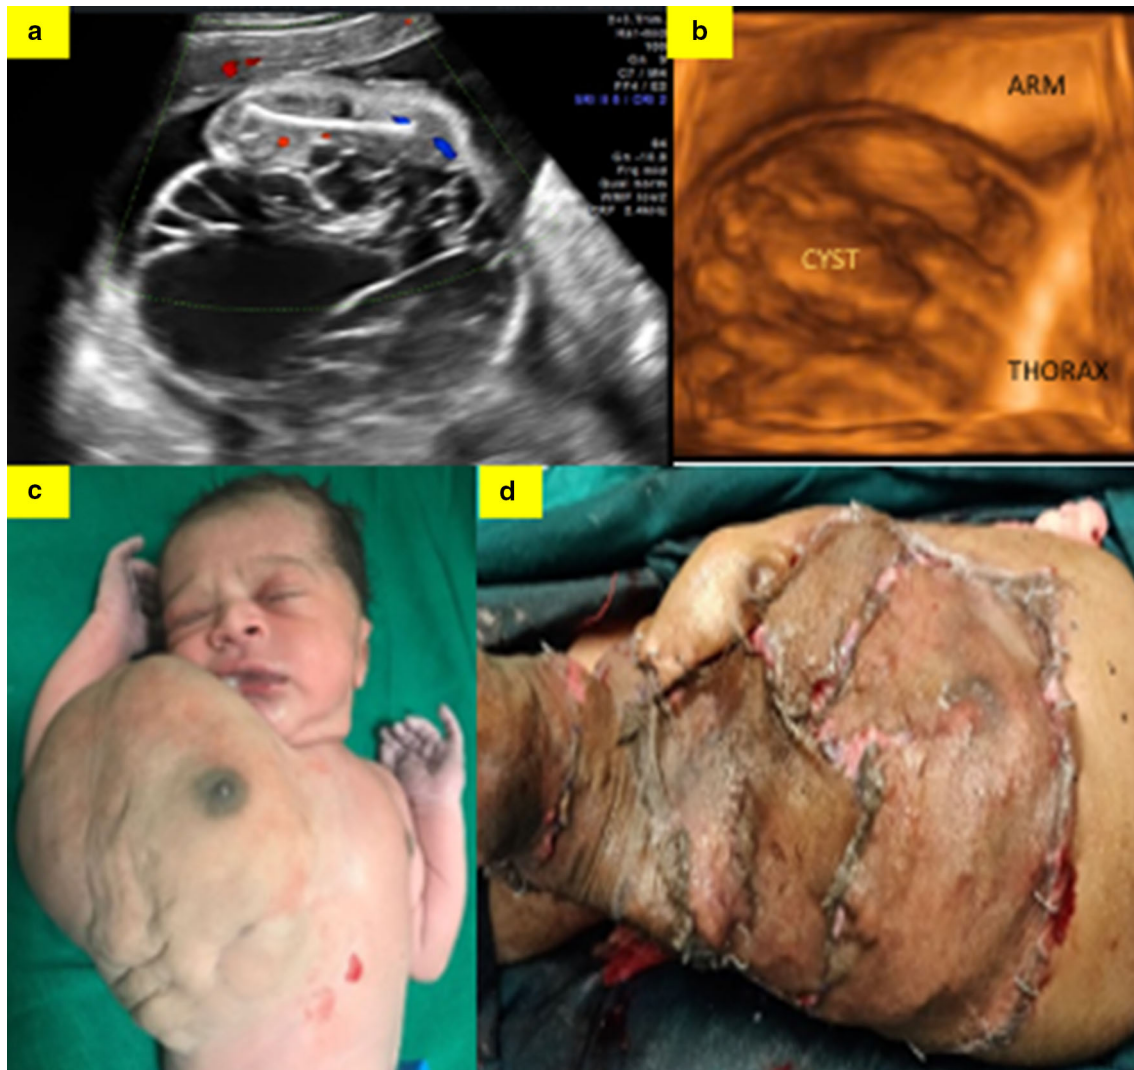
Case 1 Ultrasound scan showing large cyst with multiple septations over the right thorax extending up to the axilla and lower costal margin and wedged between the right arm and lateral chest wall. There were no solid components, no vascularity on color doppler Doppler, no involvement of underlying bone, no effusions and no intrathoracic or intra-abdominal extensions. b 3-D scan
